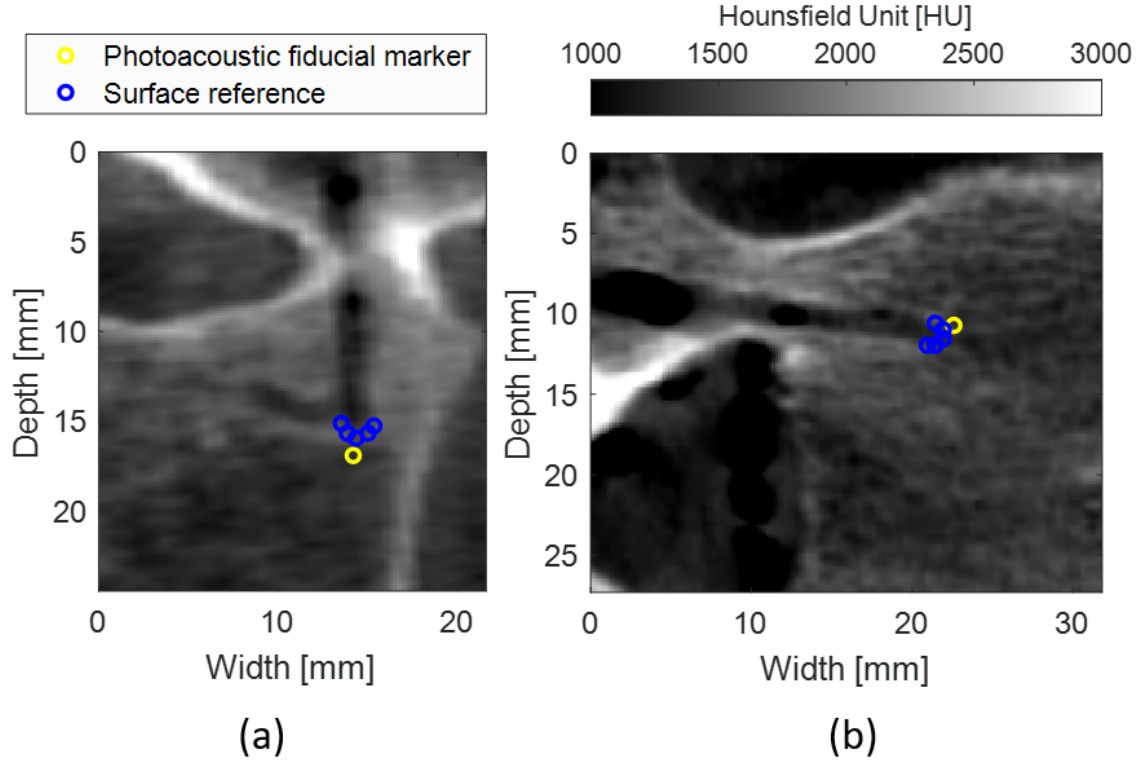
(a) X-Z and (b) Y-Z planes of the CT volume registered to the ultrasound and photoacoustic images. The yellow marker represents the centroid of the photoacoustic signal reconstructed with the LW-SLSC image, which was used as a fiducial marker for landmark registration. The blue markers show the outline of the pedicle hole.
